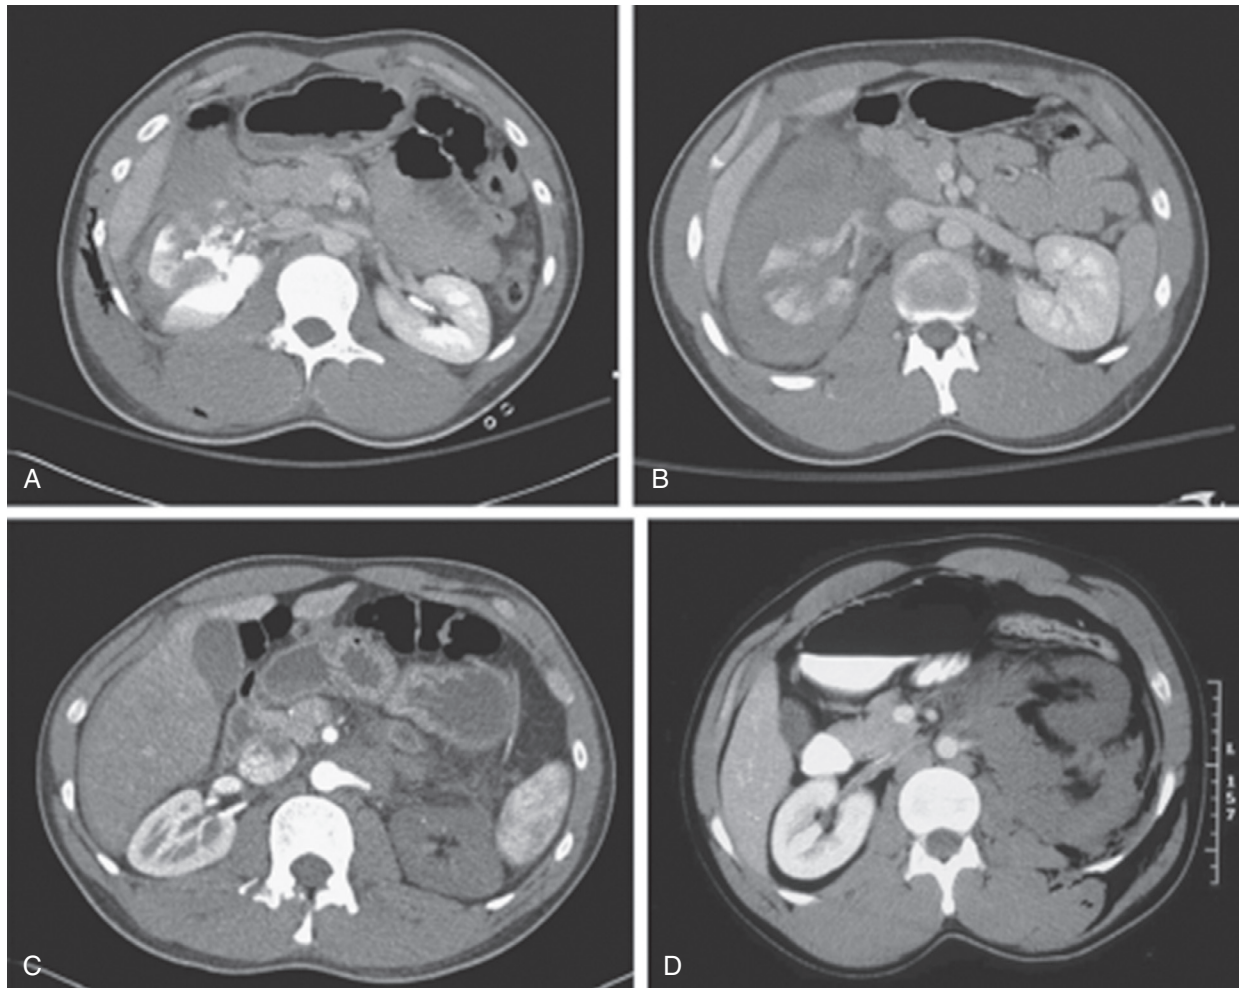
High grade renal injuries. A, Grade IV injury with urinary extravasation. B, Severe grade IV laceration, also referred to as *shattered kidney*. C and D, Grade V injuries with devascularization of the affected kidney. (From Myers JB, Brant WO, Broghammer JA: High-grade renal injuries: radiographic findings correlated with intervention for renal hemorrhage. *Urol Clin North Am* 40:335–341, 2013.)
